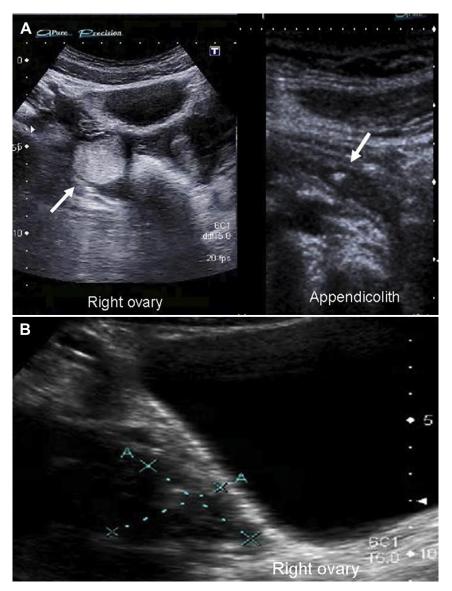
A, Preoperative ultrasound showing a right ovarian mass and an appendicolith. B, Postoperative ultrasound revealing a normal right ovary after 1 year of follow-up.
